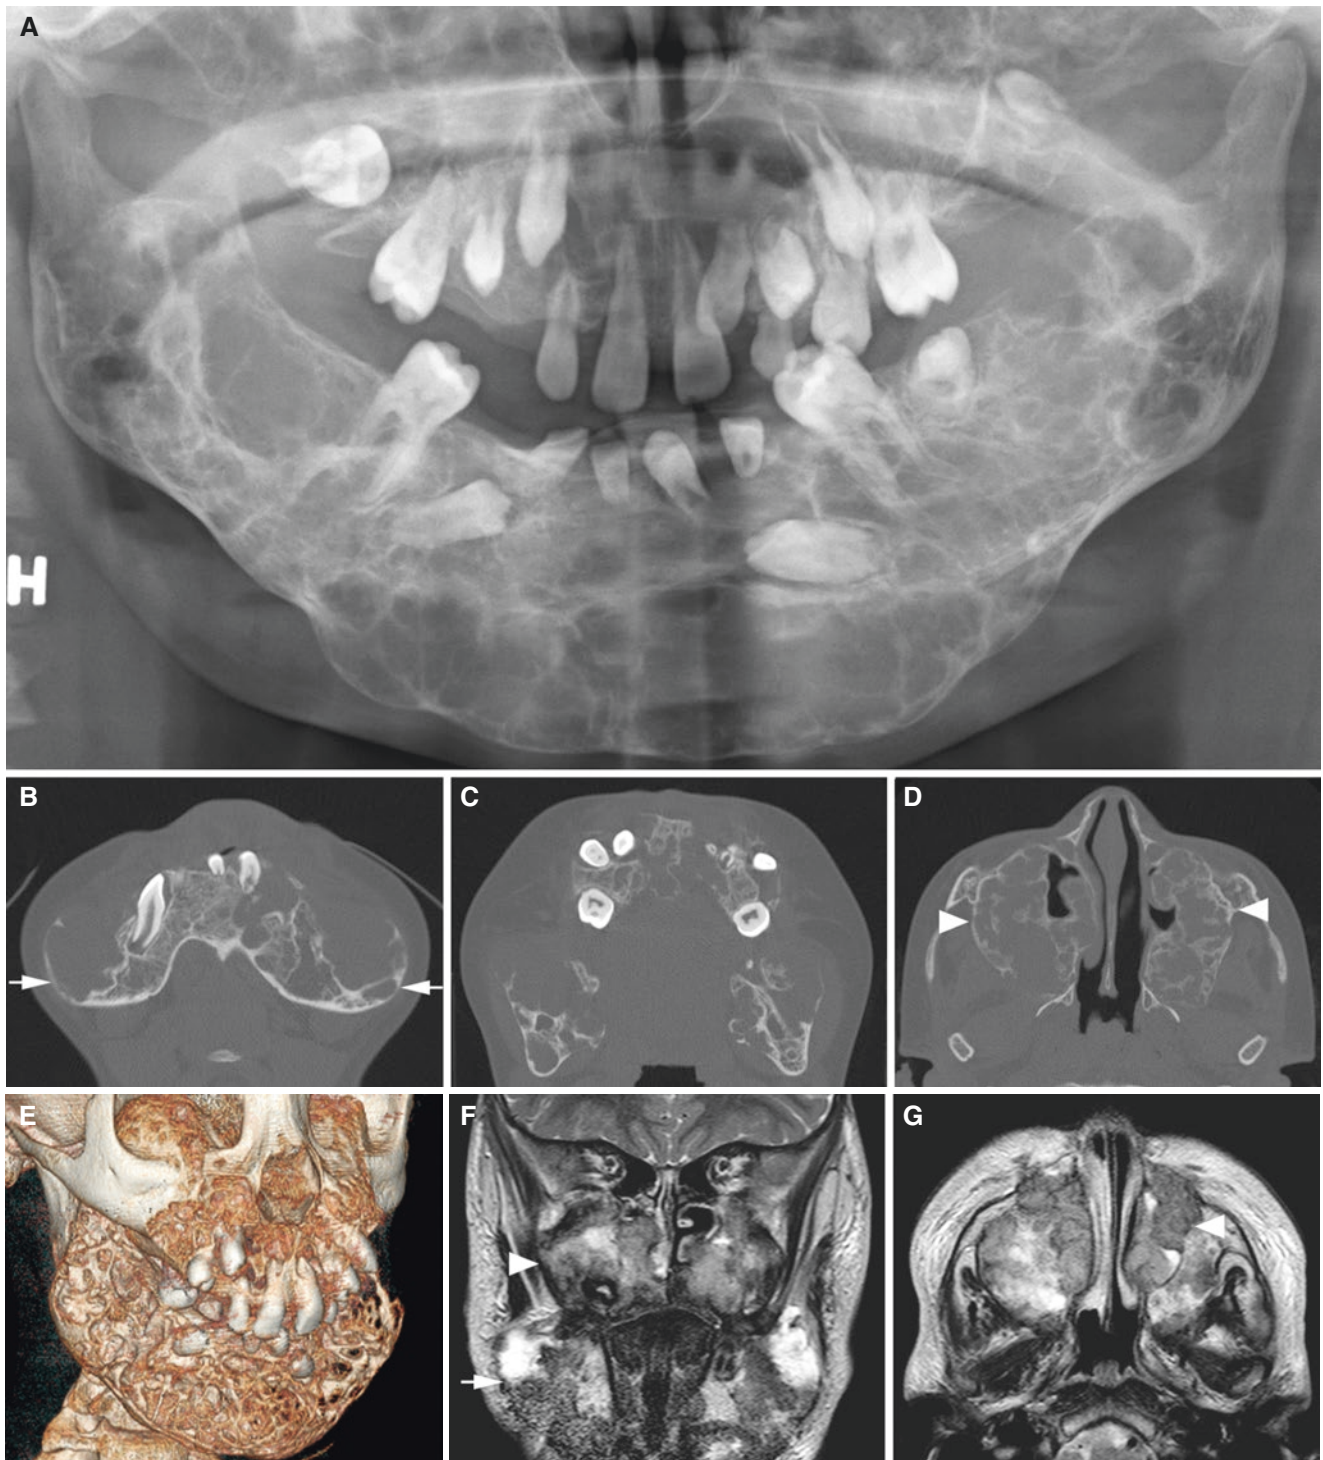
Cherubism; 10-year-old male with facial deformity. (A) Panoramic view shows multilocular radiolucencies in the entire mandible (and unerupted teeth). (B, C, D) Axial and (E) 3D CT images show multilocular lesions in the mandible (*arrows*) and maxilla (*arrowheads*). (F) Coronal and (G) axial T2-weighted MRI show heterogeneous (high to low) signal intensity lesions in the mandible (*arrow*) and maxilla (*arrowhead*)
